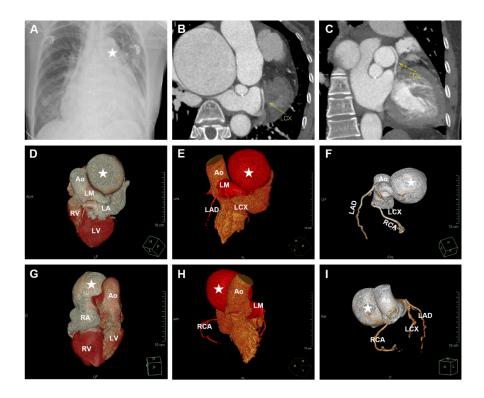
Multimodality image examination. (A) Chest X-ray shows a mass (white star) abutting the left atrium border. (B-C) Cardiac CT reveals a giant aneurysm in the distal of left coronary. (D-I) Cardiac 3D-CT indicated the origin and course of coronary arteries were normal. The left coronary sinus sent out a thick blood vessel branch, connecting a giant left main (LM) coronary artery aneurysm (white star) fistula to the right atrium. AO, aorta; LAD, left anterior descending; LCX, left circumflex; RCA, right coronary artery; LA, left atrium; LV, left ventricle; RA, right atrium; RV, right ventricle.
